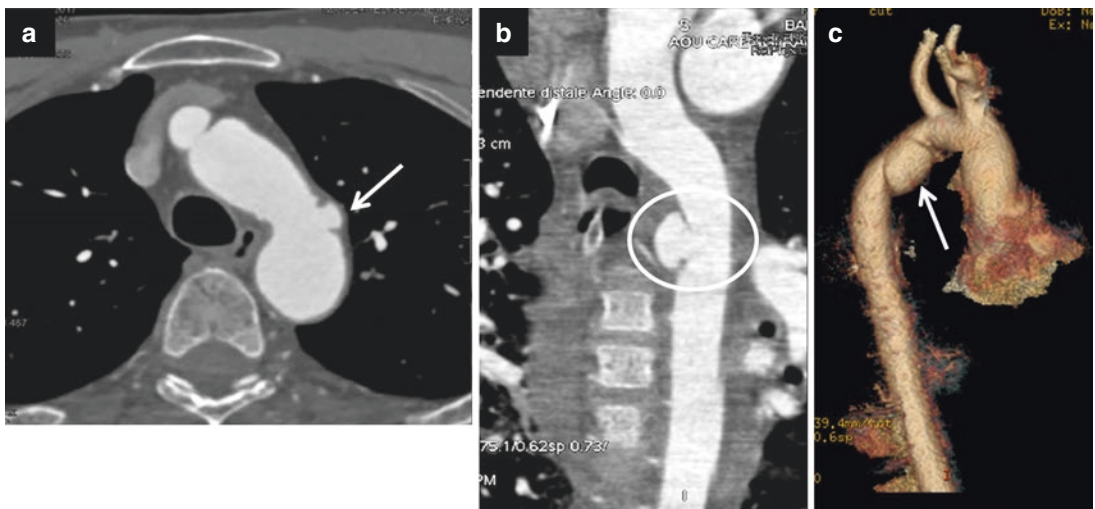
Pseudoaneurysm (acute angles with the aortic wall). (a) Axial CT scan shows small pseudoaneurysm isthmus (white arrow); (b) reformatted oblique image and (c) reformatted 3D image show large pseudoaneurysm isthmus (white circle in b and white arrow in c)
